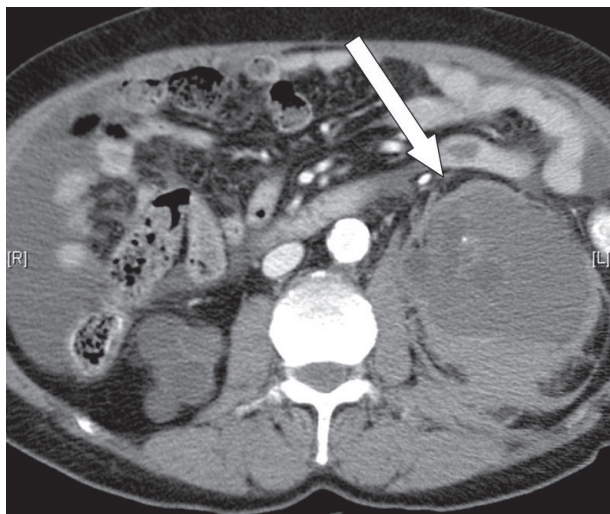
Abdominal CT. Massive hemorrhage in left kidney (arrow).
